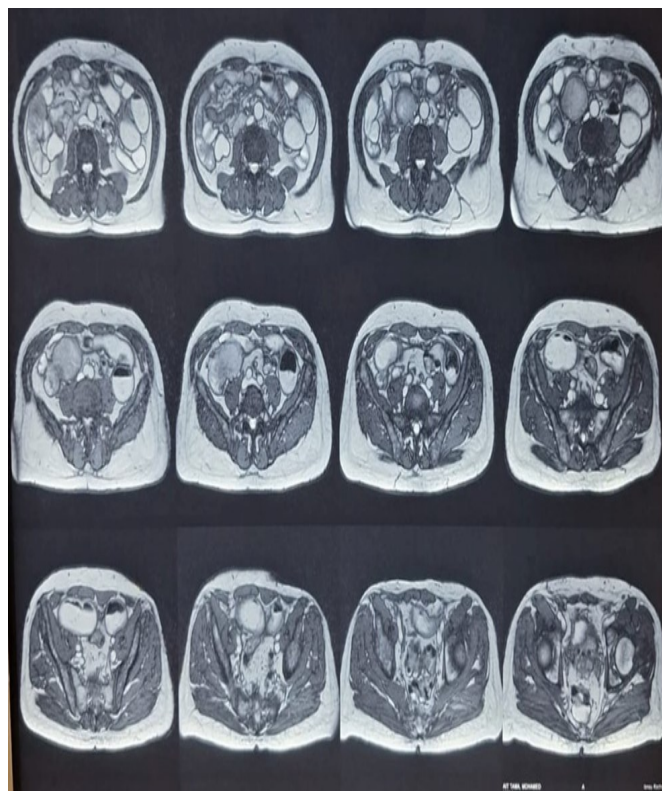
MRI slide showing the right flank tumor and its characteristics
